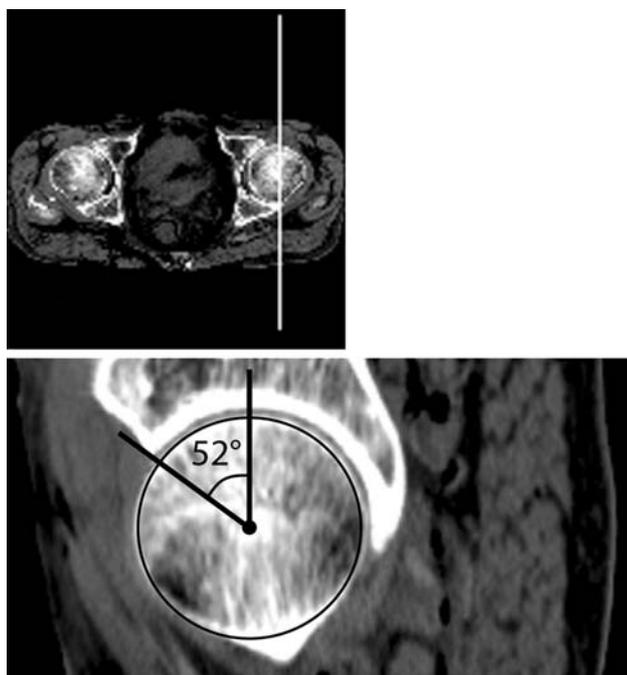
CT measurement of anterior acetabular coverage in the sagittal plane. Measurements of the anterior acetabular coverage on CT scans, was performed by using a sagittal plane CT reformations through the center of the femoral head
